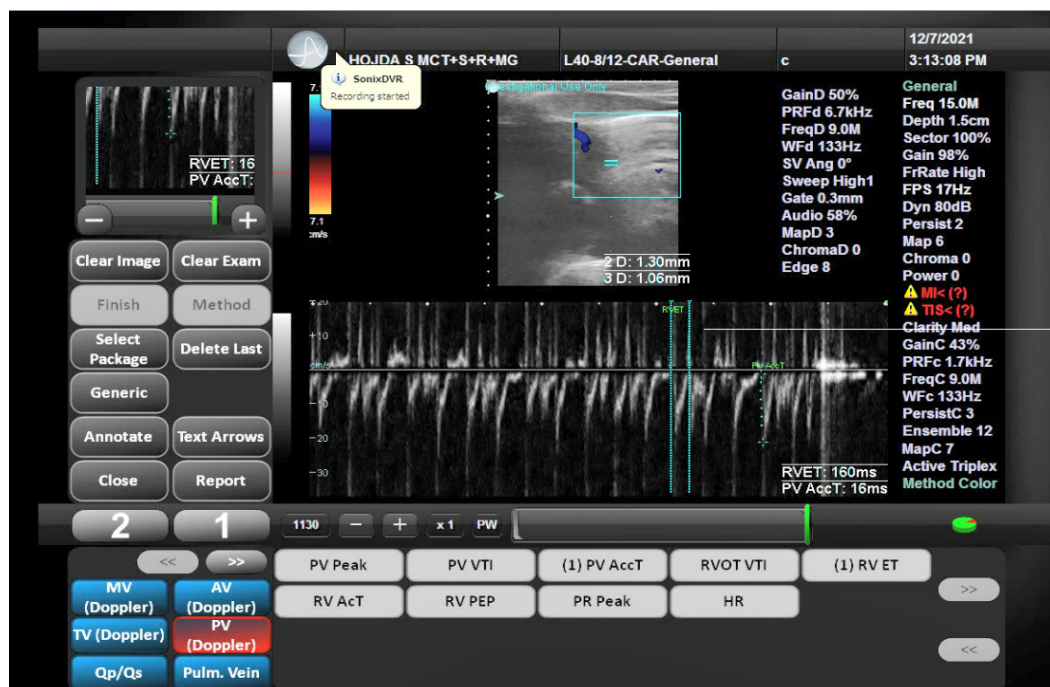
Pulmonary artery accessed by ultrasonography. Parasternal short axis view modified section. The pulsed-wave Doppler sample volume was placed in the center of PA for measurements: PAAT = PVAcT and PAET=RVET.
